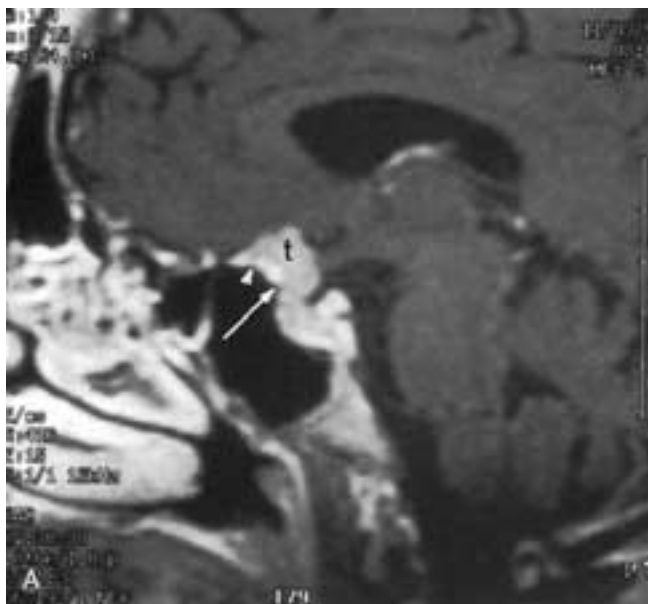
Meningioma of the chiasmatic groove and planum. A, Postgadolinium sagittal T1-weighted image shows the tumor (*t*) extending along the chiasmatic groove and onto the planum sphenoidale. The arrow indicates the position of the tuberculum sella, and the small white arrowhead indicates the limb separating the chiasmatic groove from the planum. Note how the tumor spills over into the sella turcica. B, Coronal T1-weighted postcontrast image shows the tumor (*arrow*) with intermediate enhancement. Notice the enhancement of the dural tails (*small black arrowheads*) extending in either direction from the main tumor.
